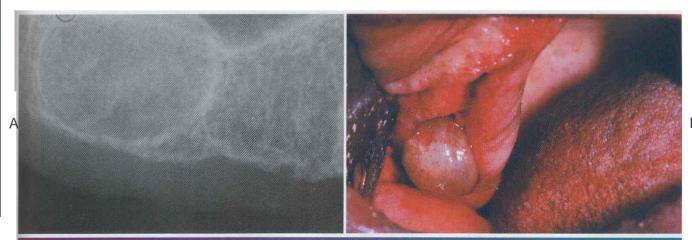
• Residual periapical cyst. A. Well-defined radiolucency of the posterior maxilla. B, Clinical photograph exhibiting soft-tissue cyst extruding from the maxillary alveolar ridge after surgical exposure of the site. (Courtesy of Dr. Denise E. Clarke.)
